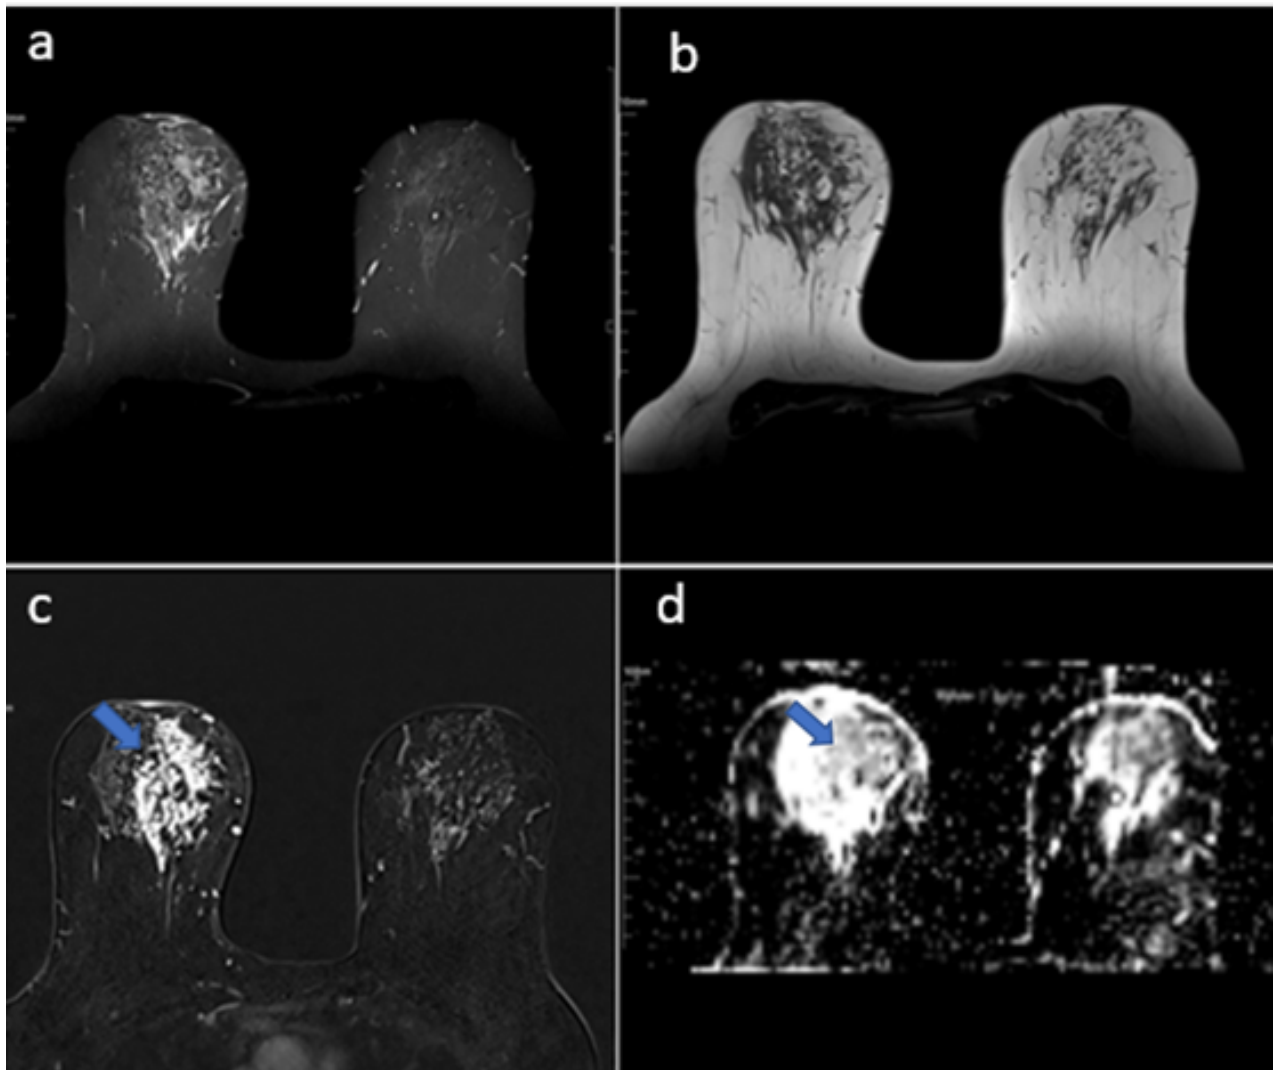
a) STIR axial b) T1-Weighted axial c) Contrast enhanced fat-suppressed T1W axial MR images; blue arrows show heterogeneous clustered intensely enhanced non-mass area filling whole upper inner quadrant of the right breast and retro areolar region. d) Diffusion restriction on diffusion-weighted imaging (arrows).
